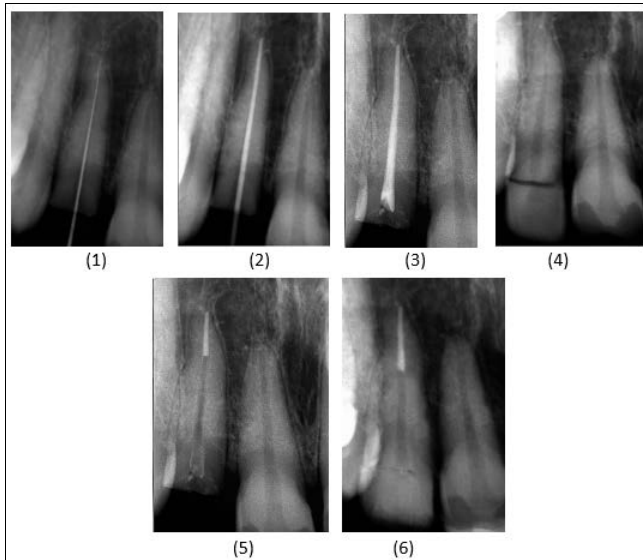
(1) Preoperative radiograph of 12 (2) working length (3) master cone (4) obturation (5) post space (6) postoperative radiograph after reattachment of fragment
